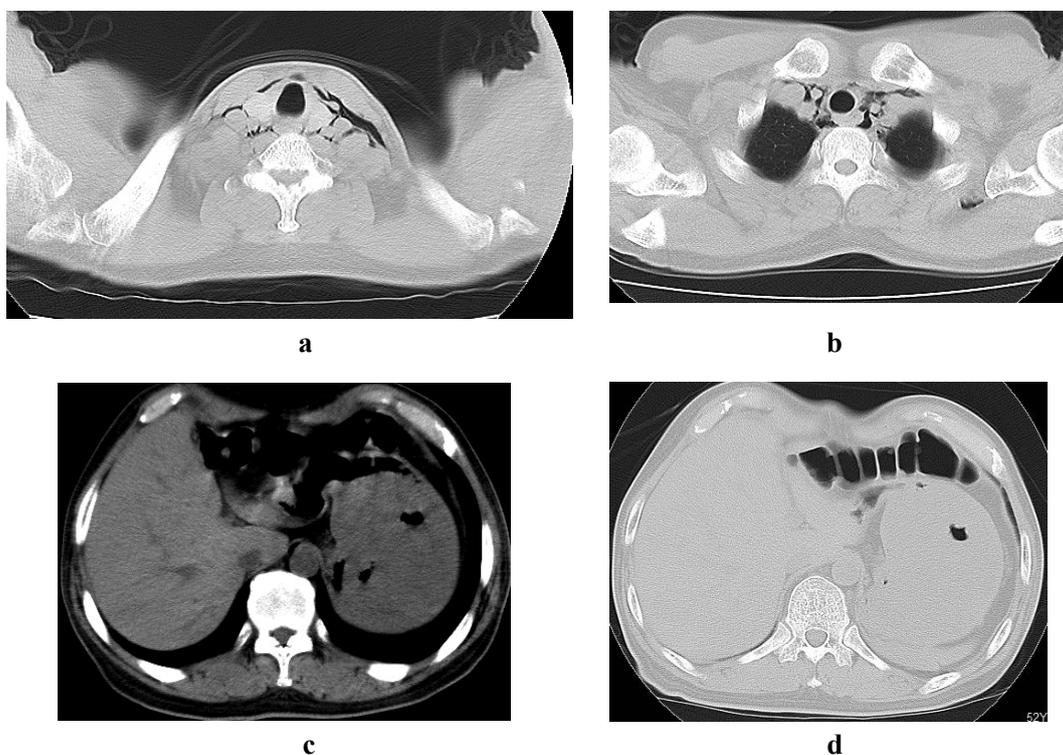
Chest and abdominal CT scans. a) Pneumoderma was observed in the neck. b) Pneumomediastinum was detected in the chest, but no marked pneumothorax was observed. c) The tumor was found in the upper part of the gastric stomach (arrow indicates tumor). d) No emphysema was detected in the abdominal cavity.
